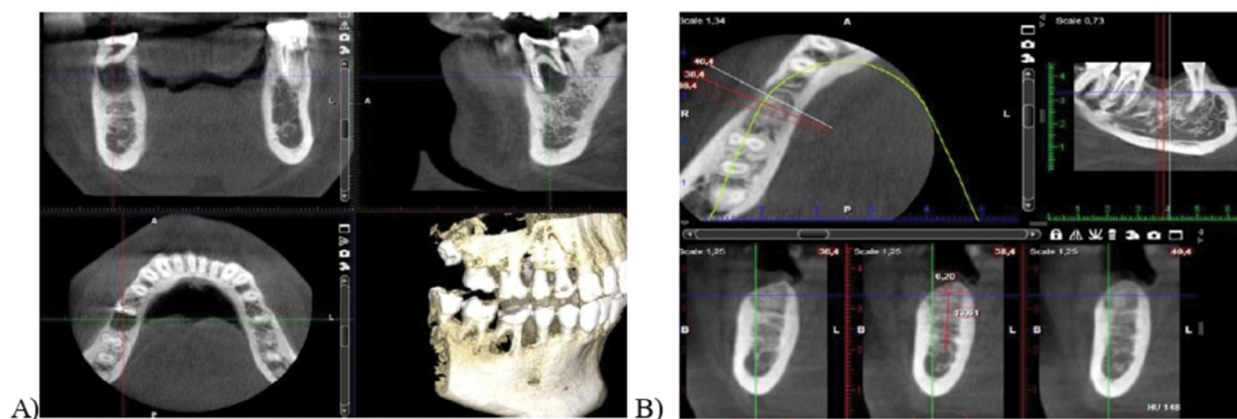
A) CBCT imaging of the lesion around the roots of 46; B) CBCT imaging after 6 months.
